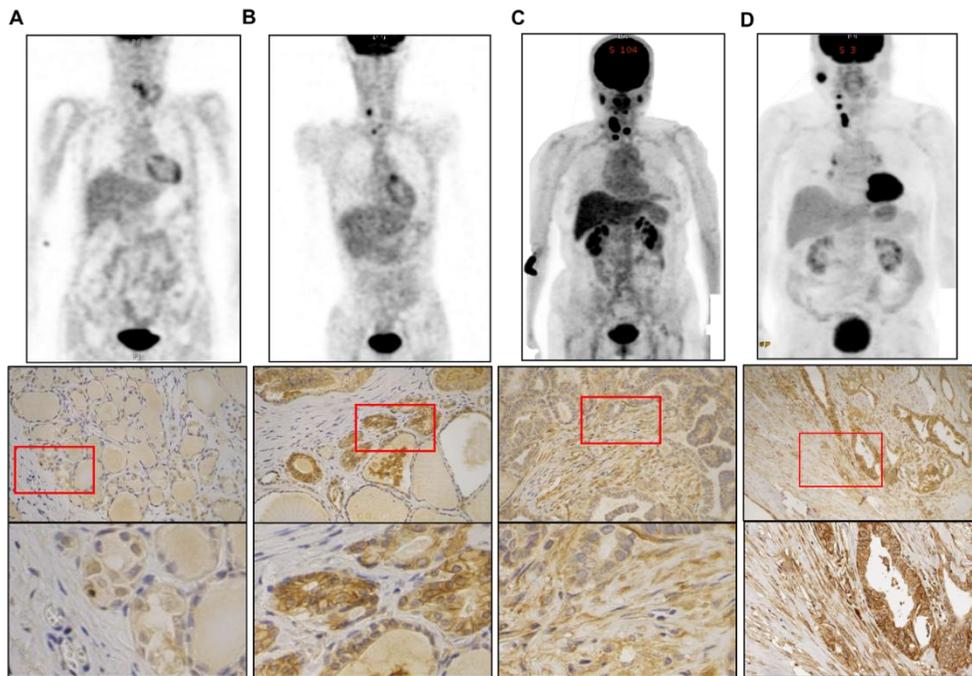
Representative 18F-FDG-PET/CT images according to MCT4 expression pattern.
